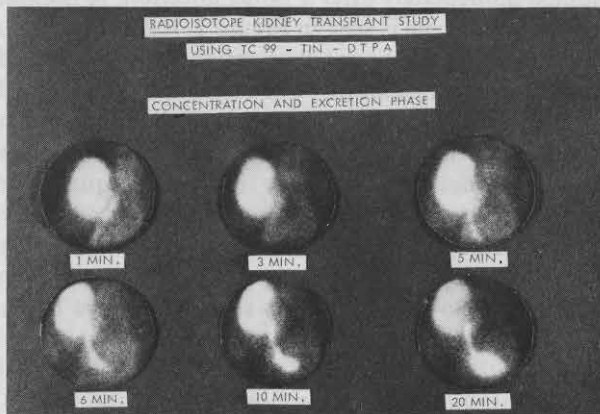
Normal scintigraphic transplant study of excretion phase using  $^{99\text{m}}\text{Tc}$ -Sn-DTPA. Kidney, ureter, and bladder are clearly seen.
